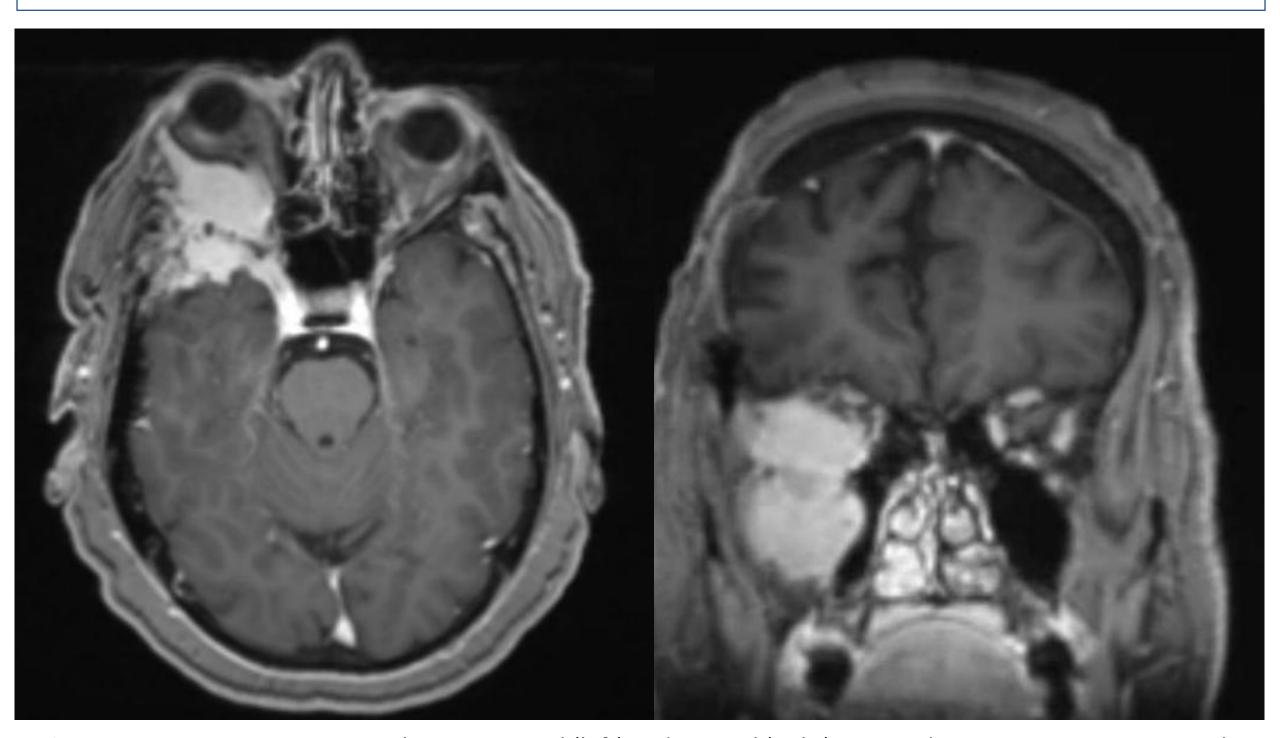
Preoperative MRI T1 with contrast axial (left) and coronal (right) images demonstrating recurrent right spheno-orbital memingioma with significant extension inferiorly to the infraorbital compartment
